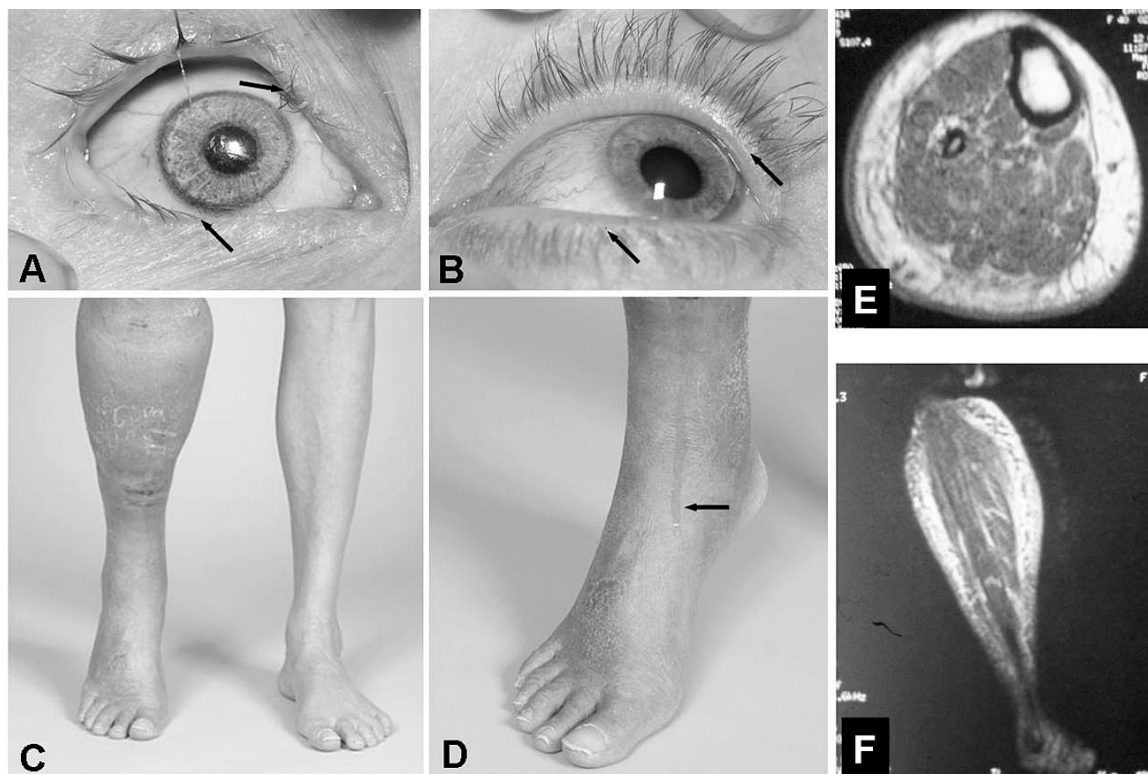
(A,B) Bilateral distichiasis. Arrows point to extra eyelashes inside the gray zone. (C) Brawny right leg lymphedema below the knee. The left leg is edema free. Higher magnification displays clear yellow fluid (arrow) weeping from the pre-tibial area (lymphorrhea) (D). Magnetic Resonance Imaging of the lower right leg (E, transverse; F, coronal) demonstrates prominent edema in subcutaneous tissue space with characteristic honeycomb pattern and absence of edema in the muscular compartment.
